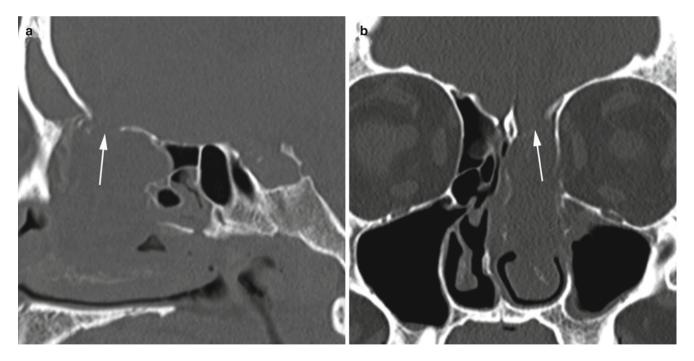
CSF leak. (a) Sagittal CT image without contrast. (b) Coronal CT image without contrast. In both images, a bony defect is seen in the roof of the left ethmoid (*arrows*), with complete opacification of the left ethmoid air cells and part of the left nasal cavity
